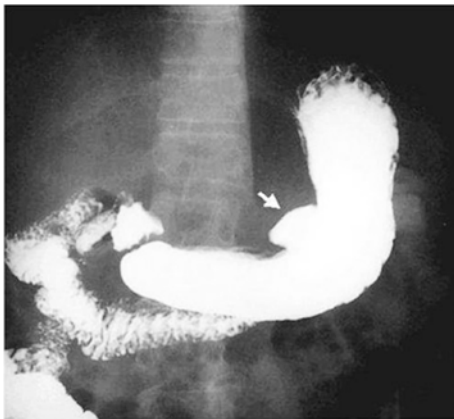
X-ray: gastric ulcer, type I (arrow)
